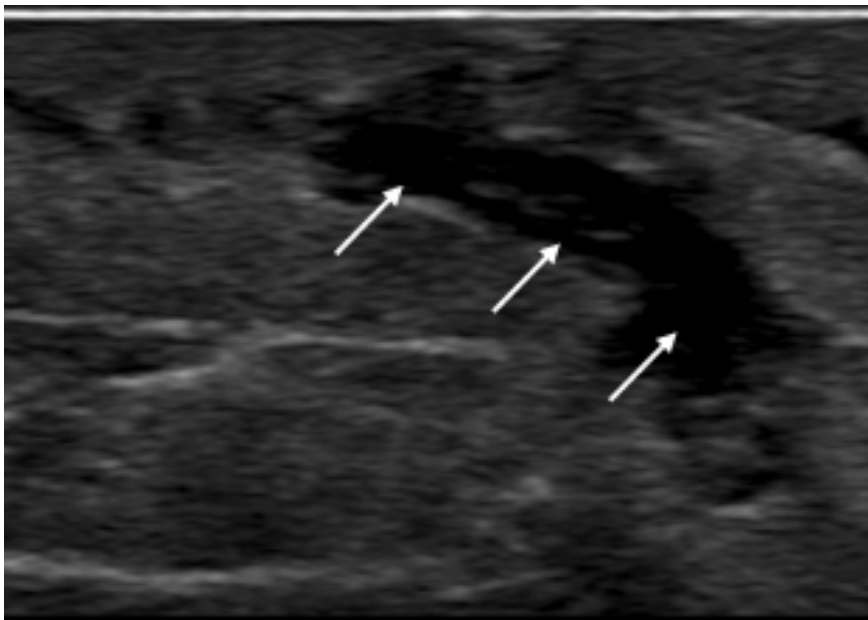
An ultrasonography scan of the right axilla demonstrated branching anechoic areas (arrows) in the subcutaneous tissues with thickened and echogenic overlying skin layers. No organized abscess collections were present, and increased vascularity was noted on color flow imaging compatible with subcutaneous phlegmon.
